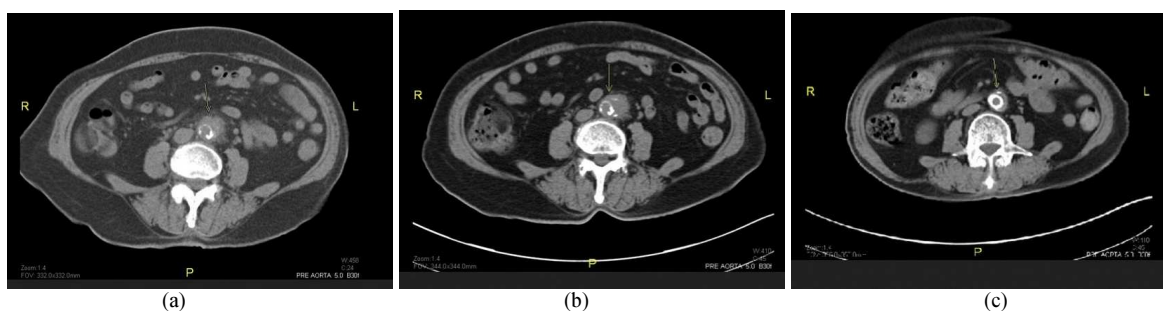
Abdominal CT scan showing: 1(a) marked soft tissue changes in the infrarenal aorta with involvement of the surrounding mesenteric vasculature and associated wall thickening of the aorta (arrow), (b) decreased periaortic inflammatory changes but new outpouching of contrast arising from the infrarenal aorta at the site of the previously seen arteritis, suspicious for a pseudoaneurysm (arrow), (c) improving inflammatory changes and decreased size of the pseudoaneurysm, stent can also be visualized (arrow)
